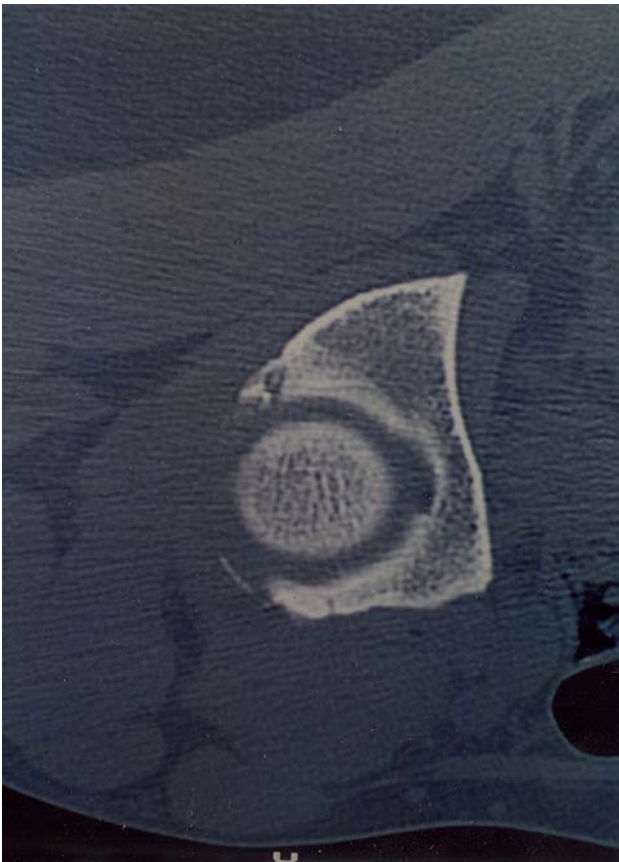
CT scan showed the typical feature of osteoid osteoma: osteodense lesion with radiolucent borders and surrounding sclerosis
